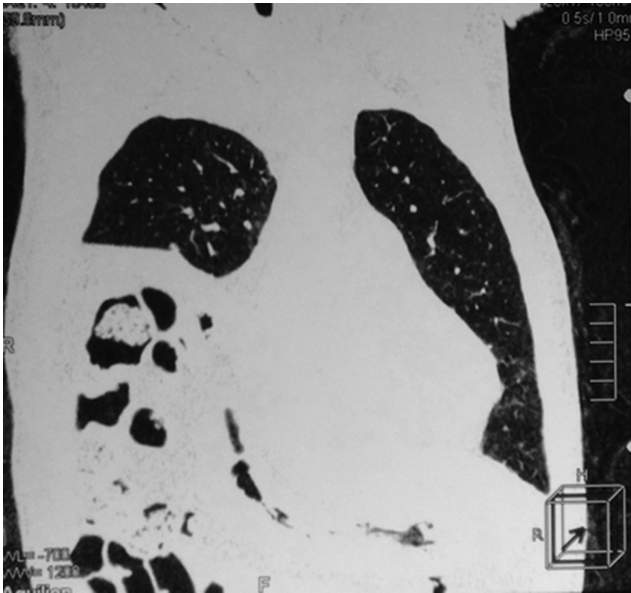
Computed tomography shows that the right lung is significantly compressed and that the transverse colon appears in the right chest cavity.
